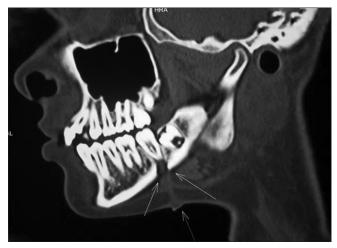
MRI showing osseous defect in mandible
